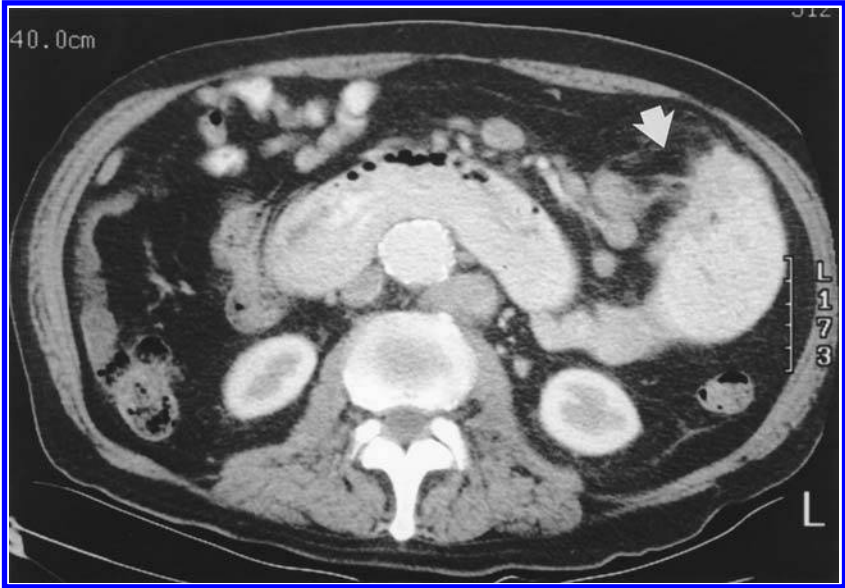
CT scan of metastatic lung carcinoma of the small bowel (arrow).
